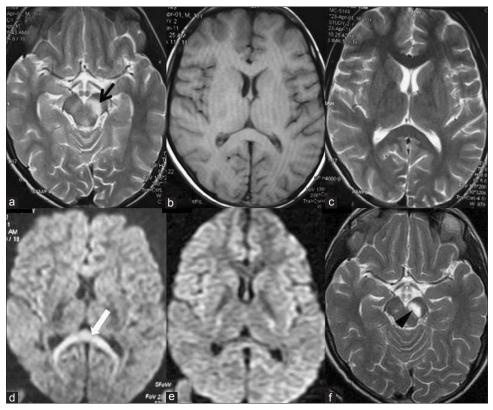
Magnetic resonance imaging (Brain) of case 4, with post-infectious parkinsonism, showing hyperintense signals in bilateral substantia nigra on axial T2-weighted image (a), more pronounced on left side; T1-weighted (b) and T2-weighted (c) images, axial section, focussing on the corpus callosum appear normal while a uniform hyperintensity of the splenium of corpus callosum ("Boomerang sign") on diffusion-weighted image (d) is evident. Repeat diffusion-weighted image (e), done after 10 days, depicting reversibility of lesion involving the splenium of corpus callosum; the hyperintense signals involving the substantia nigra on axial T2-weighted image (f) decreased in size
